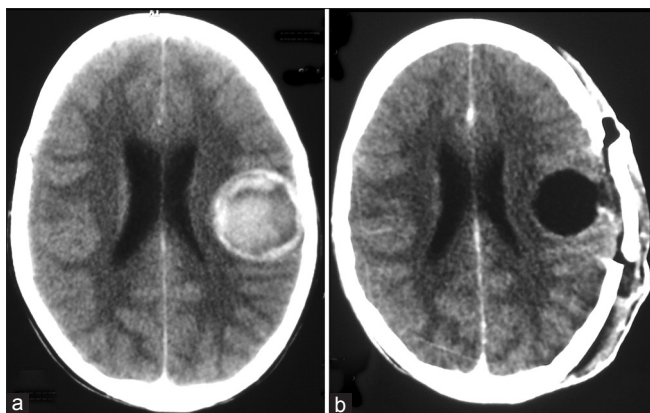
(a) CT scan brain plain showing well-defined lesion in left temporoparietal region with evidence of hemorrhage, (b) Follow-up CT scan showing complete excision
